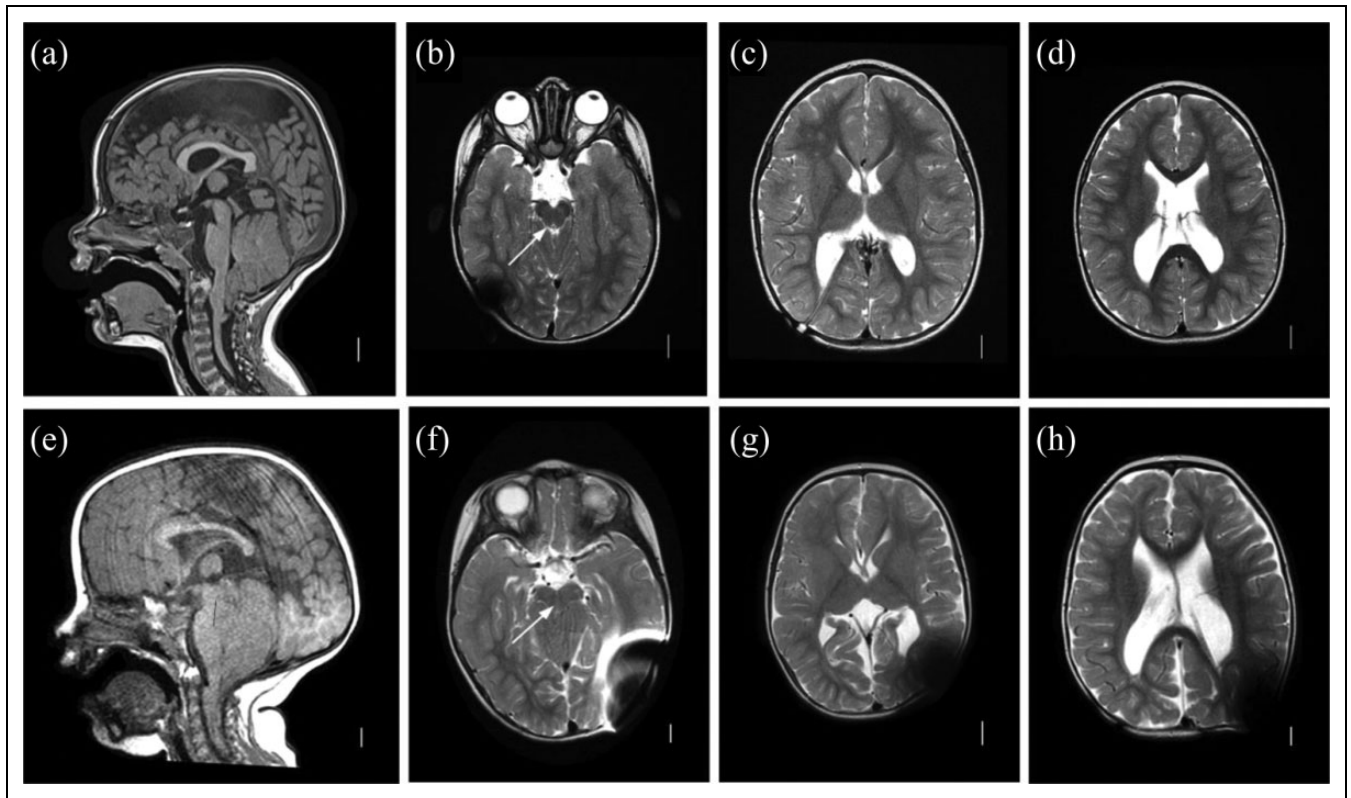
Myelomeningocele-associated hydrocephalus. (A-D) Classic Chiari II malformation. Sagittal T1 magnetic resonance image (MRI) demonstrating classic features of a Chiari II malformation including elongated pons and downwardly displaced medulla, tectal beaking, small posterior fossa with vertically oriented tentorium, with cerebellar tonsillar ectopia below the foramen magnum line (A). Axial T2 images (B-D). Note patency of aqueduct in B (arrow). (E-H) Chiari II with aqueductal compression. Sagittal T1 image (A) demonstrating similar anatomic configuration as A but with more prominent posterior fossa crowding and aqueductal compression. Axial T2 images (F-H). Note absence of patent aqueduct in F (arrow).
